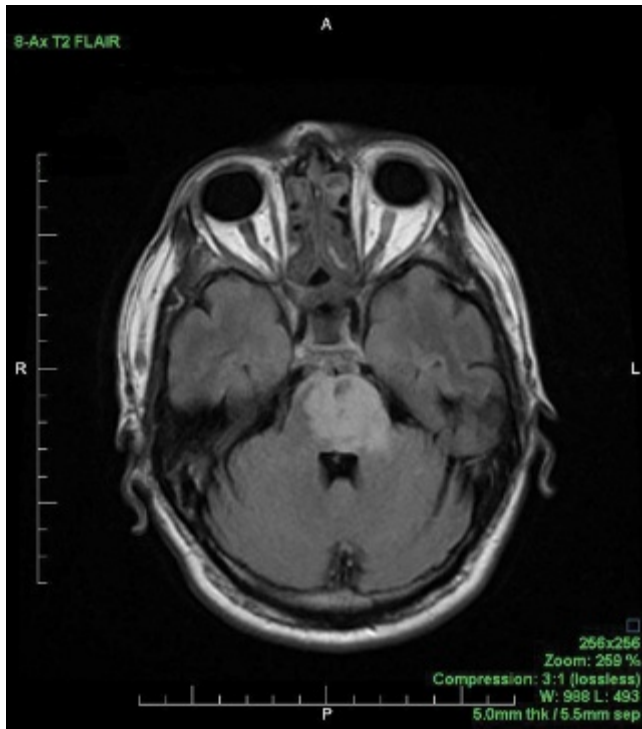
Magnetic resonance image showing bilateral infarctions of the ventral pons, more pronounced on the left, with markedly diminished perfusion of the pons.
